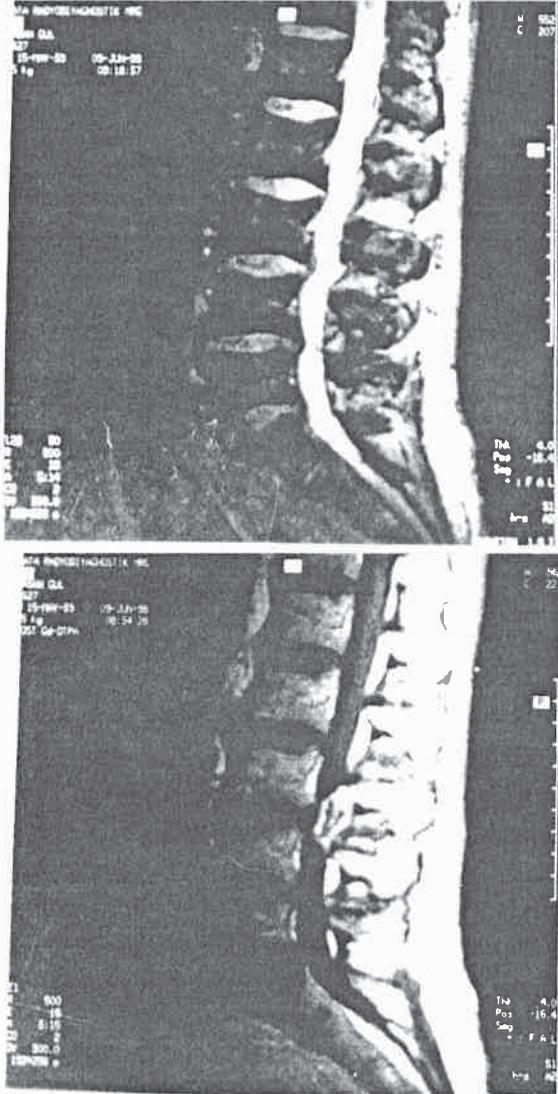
Sagittal T1-weighted magnetic resonance images at L3-L4 before (a) and after (b) contrast enhancement.
